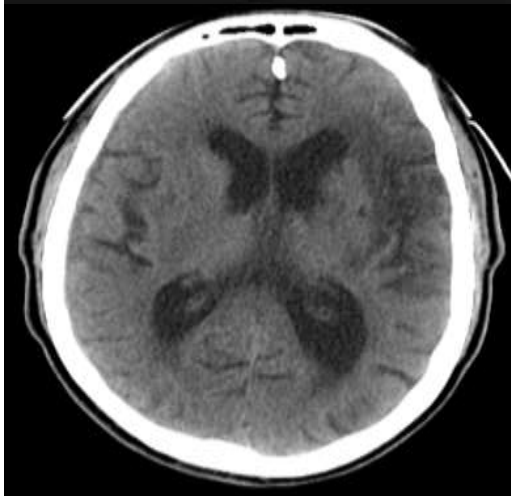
A 63 year old male patient known with HTN, dyslipidemia and obesity, with postoperative right sided hemiplegia and right gaze palsy, CT brain showed left middle cerebral artery territory infarction.
